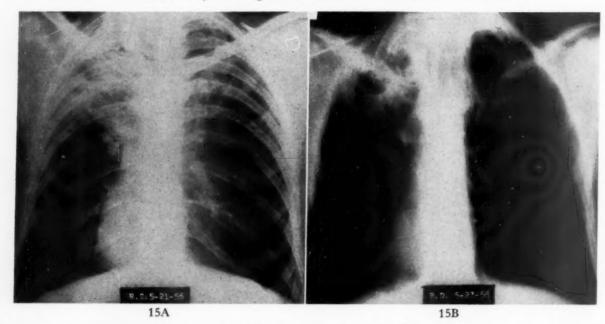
Case xi. Chest roentgenograms. A, regular anteroposterior. B, planigram showing large infiltrative lesion in the left upper lobe containing multilocular cavities.
